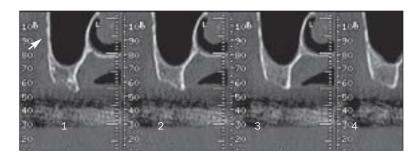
Transversal view of the CT scan of a left sinus: in the inferior third of the sinus cavity, the artery is divided into 2 parts. On these views, the arteries are inside the bone. PSAA (arrow).
